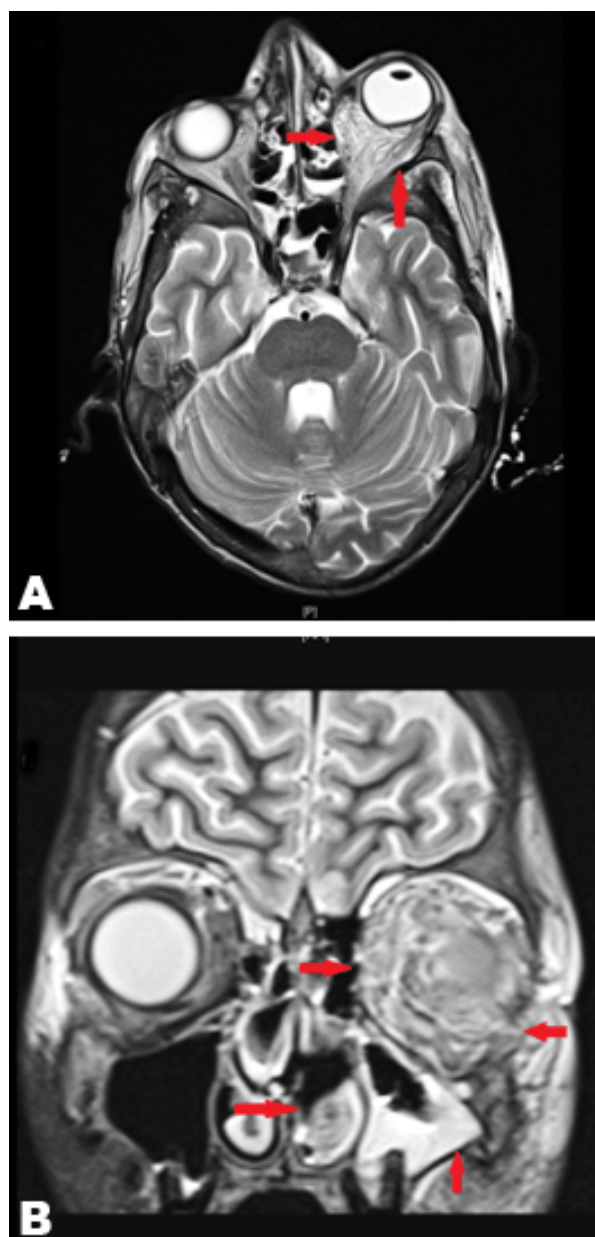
(A, B): Magnetic resonance imaging scan of brain and orbits showing extensive involvement of left orbit and some involvement of right orbit, left maxillary antrum and ethmoidal sinus.
